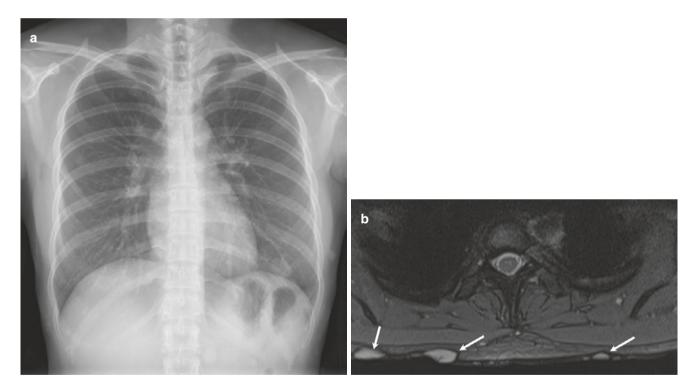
Neurofibromas mimicking lung nodules in a patient with neurofibromatosis type 1. (a) Frontal chest radiograph shows small nodular opacities in bilateral lower zones. Note incomplete border sign. (b) Axial T2* MRI image reveals multiple cutaneous neurofibromas
